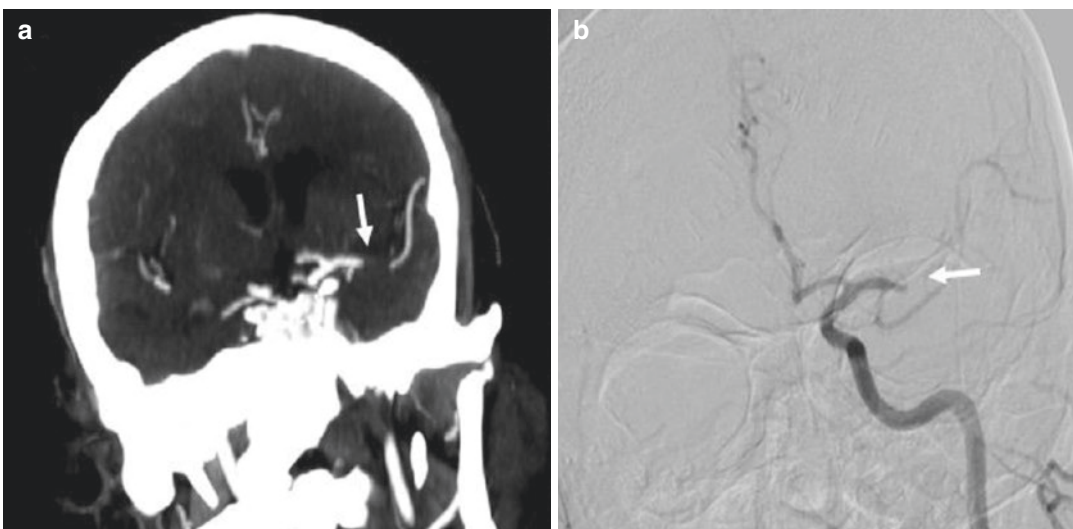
CTA MIP image (a) and DSA (b) showing occlusion of left MCA M1 segment
